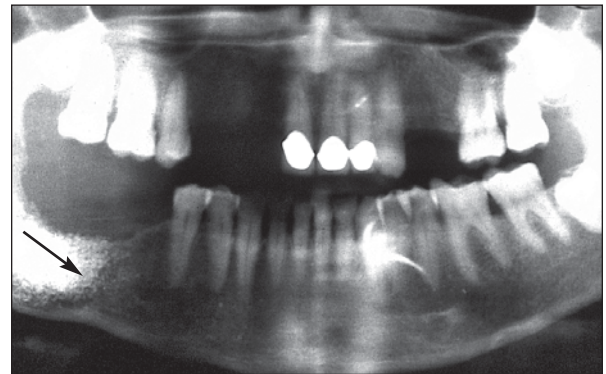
Encapsulation, appearing as a fibrous halo (arrows) in the panoramic radiograph.Fig 2b Panoramic radiograph demonstrating osseous voids (arrow).Fig 2c CT scan demonstrating osseous voids (arrow).Fig 2d Panoramic radiograph demonstrating irregular radiolucency (arrows).
